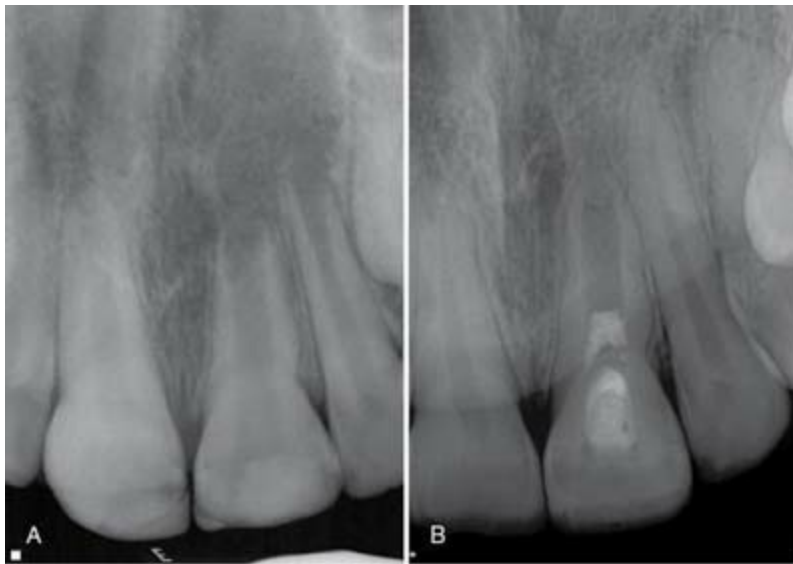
A, Preoperative radiograph showing an immature incisor (tooth #9) that sustained an uncomplicated crown fracture where pulp necrosis developed as shown by cessation of root development when compared with tooth #8. B, A 6-year review radiograph showing the tooth after treatment with a regenerative endodontic protocol. There were no signs of infection (primary goal). Calcific material at the apex is present indicating apical closure. A quantitative analysis as described by Bose et al.⁴⁴ reports a 1.9% increase in root length and a 5% increase in canal wall width (secondary goal). The tooth was responsive to electric pulp testing in a comparable range to tooth #8 (tertiary goal).
